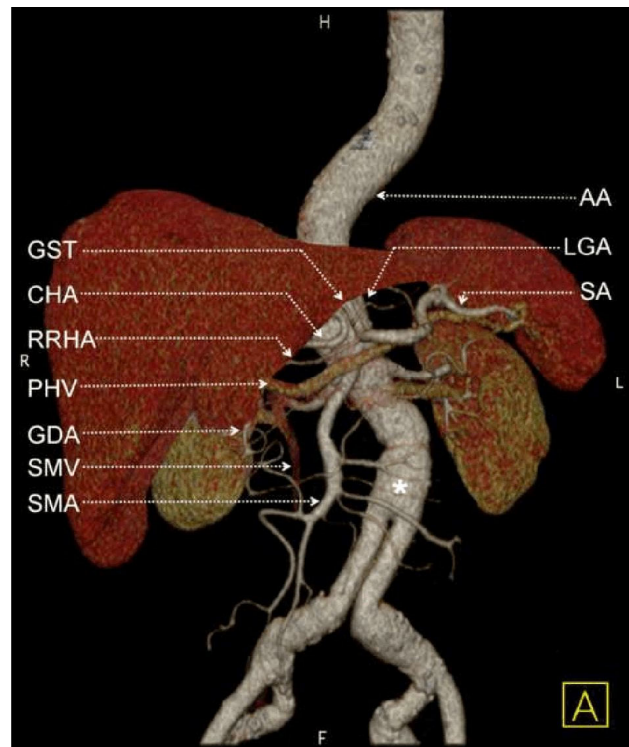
MDCT angiography of the AA, GST, CHA and RRHA. The 3D VRT (A) and MIP (B) images of AA revealed a GST in association with a CHA independently arising from the AA and the RRHA arising from the phrenic artery. 3D: Three-dimensional; AA: Abdominal aorta; CHA: Common hepatic artery; GDA: Gastroduodenal artery; GST: Gastrosplenic trunk; HP: Head of pancreas; LGA: Left gastric artery; LHA: Left hepatic artery; LIPA: Left inferior phrenic artery; MDCT: Multidetector computed tomography; MIP: Maximum intensity projection; PHV: Portal hepatic vein; RB-PHA: Right branch of portal hepatic vein; RIPA: Right inferior phrenic artery; RRHA: Replaced right hepatic artery; SA: Splenic artery; SMA: Superior mesenteric artery; VRT: Volume rendering technique; *: Level of in situ functional aortoiliac prosthetic graft.
